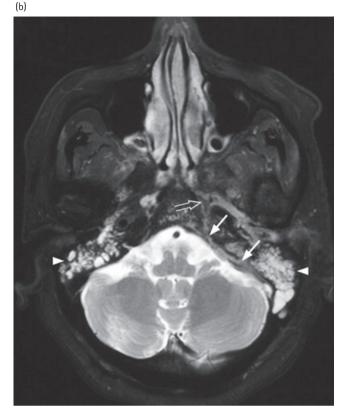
Magnetic resonance imaging (MRI) scan of skull base in a 59-year-old male with a 20-year history of diabetes (with nephropathy), treated with insulin who developed severe extensive invasive aspergillosis. He presented with headache and vertigo followed by left sixth and seventh nerve palsies. He subsequently developed bilateral sensorineural hearing impairment and blindness secondary to extensive skull base infiltration by the invasive aspergillosis. MRI demonstrated enhancing soft tissue closely related to the left posterolateral wall of the nasopharynx with parapharyngeal, skull base, perineural and dural infiltration. Biopsy showed inflamed fibrous tissue with degenerated fungal filaments. Culture confirmed *Aspergillus flavus*. He is receiving lifelong therapy with voriconazole. He remains blind. MRI of skull base in the axial plane with:
